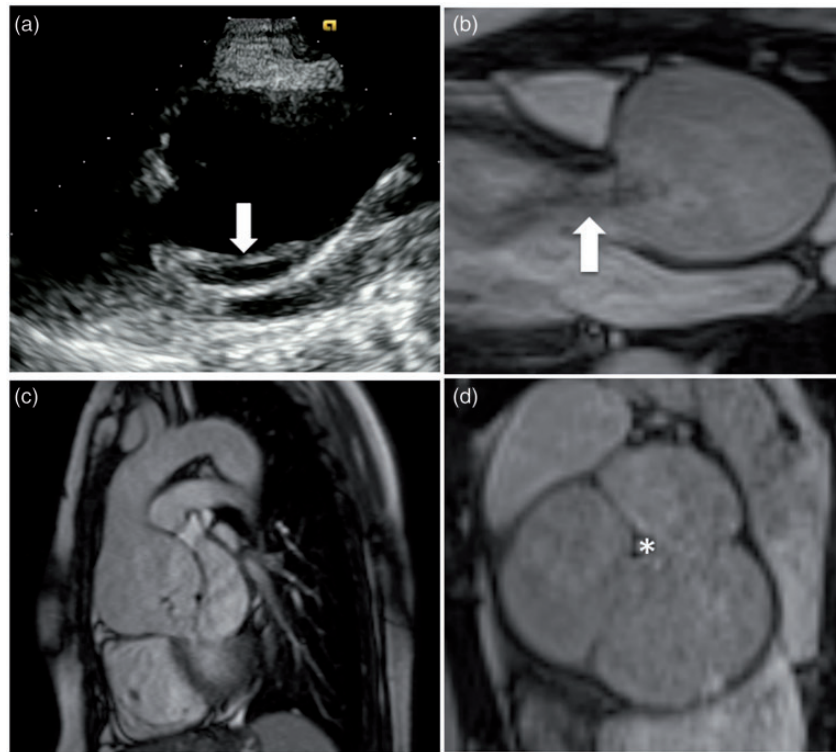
Twenty-eight-year-old woman with Marfan syndrome who presents at 13 weeks' gestation for evaluation. A parasternal long axis echocardiographic image demonstrating a dilated aortic root and an echogenic line (arrow) suspicious for a dissection flap at the noncoronary cusp (a). Corresponding cardiovascular magnetic resonance imaging (CMR), steady state free precession (SSFP) image shows no evidence of a dissection flap (b). Therefore, the finding on transthoracic echocardiogram was thought to be artifact. Notice the severe aortic regurgitation jet (arrow). A sagittal oblique SSFP MR image demonstrating severe dilation of the aortic root with no evidence of a dissection flap (c). A short axis SSFP MR image in the aortic valve plane shows a dilated aortic root measuring up to 59 mm and central coaptation defect (*) as the cause for the severe aortic regurgitation (d).
